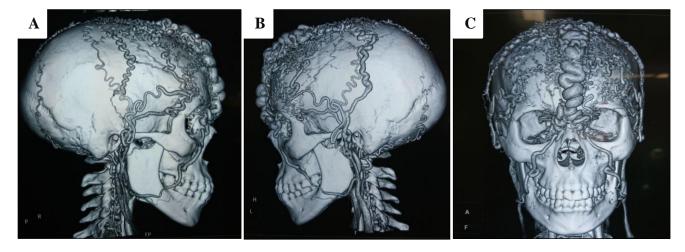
Three-dimensional CT angiography (3D-CTA) showed prominent vessel. (A): angular artery, (B): Supratrochlear artery, (C): Left and right superficial temporal artery.
